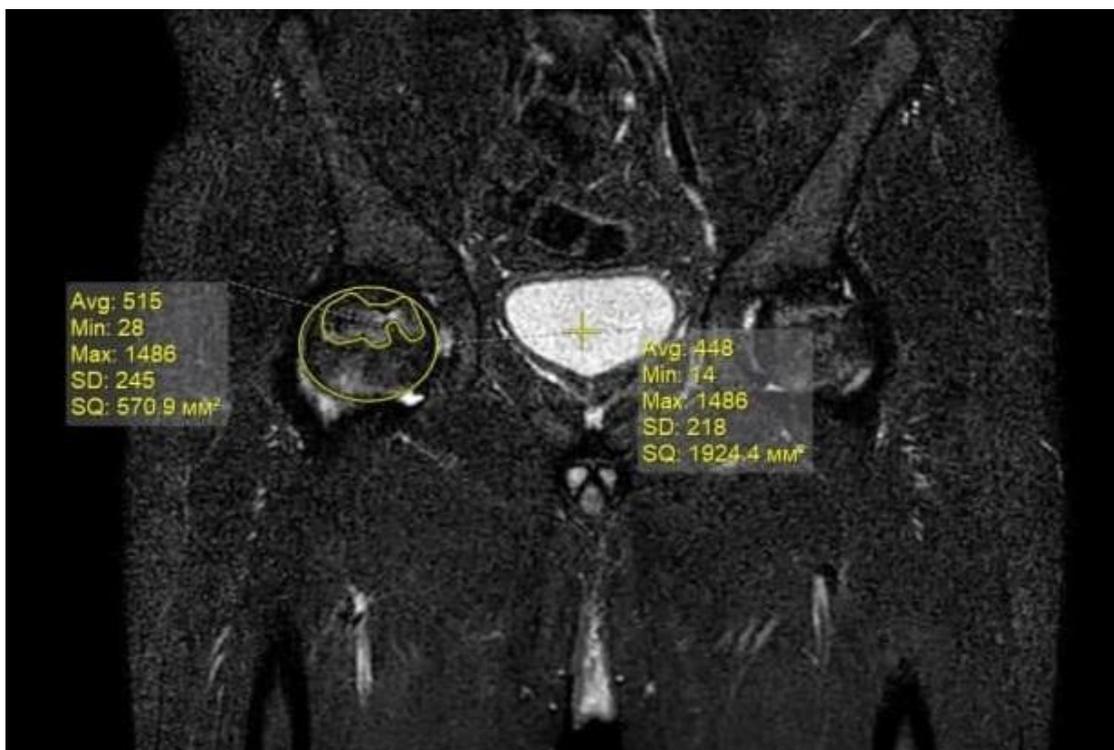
MRI of patient M.Yu., born in 1963, No. IB 9163/870, with stage III of ANFH disease, 6 months after plasma lifting.
